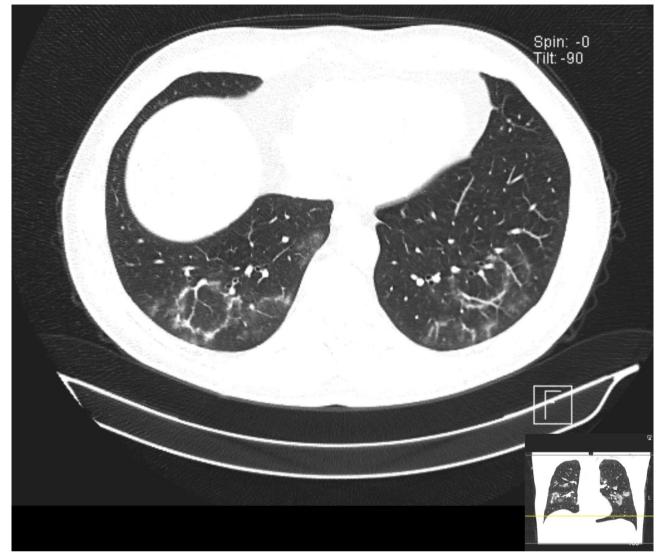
Chest CT findings of typical COVID-19 pneumonia (12th day from the onset of symptoms; CT score 14)
